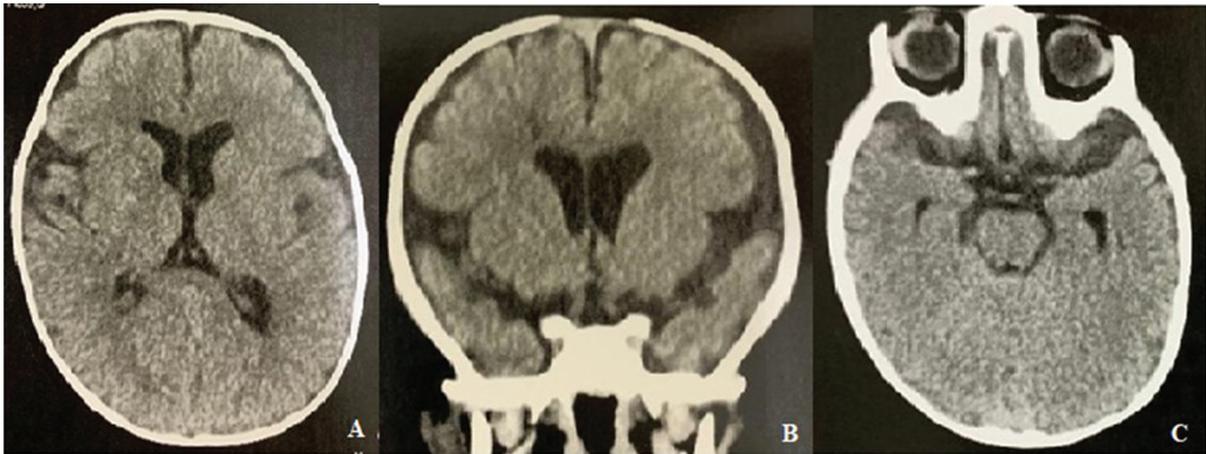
Postoperative cranial computed tomography (CT) scan showing a reduction in ventricular cavities. (A, C) Axial section of skull CT. (B) Coronal section of skull CT.
